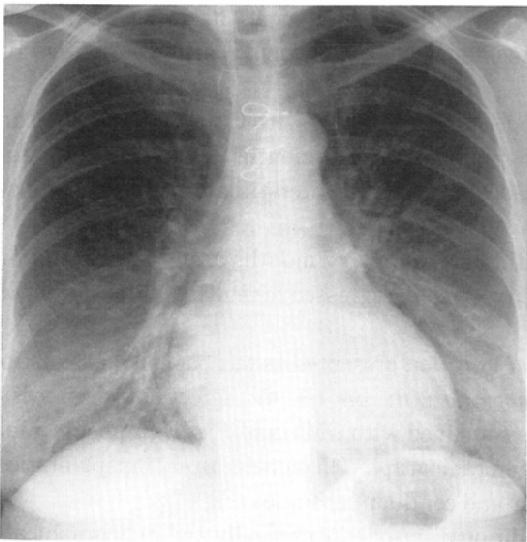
(Case 3) *P. carinii* pneumonia. PA chest radiograph 2.0 months after cardiac transplantation shows diffuse air space shadowing overlying on the diffuse interstitial opacities.
